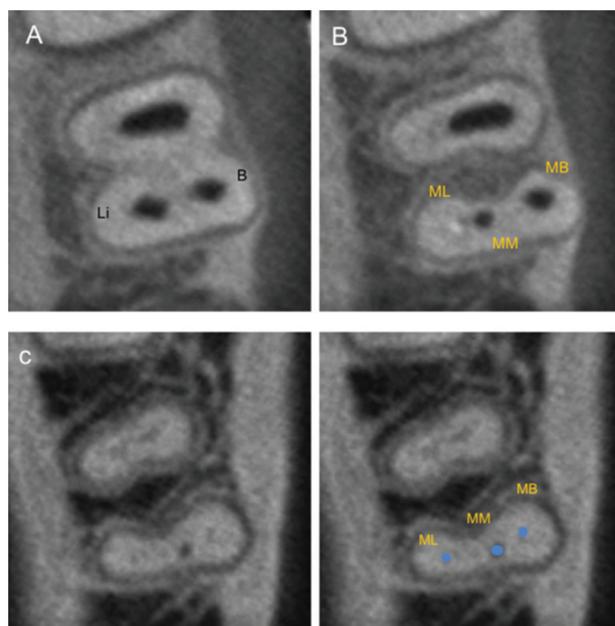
CBCT images of middle mesial canal that was the independent type: (A) At the orifice level, 2 canals were observed. (B) At 1 mm below the orifice level, there was an additional canal, which was the mesiolingual canal. The canal that was previously located next to the mesiobuccal canal was middle mesial canal. (C) At the apex of root, all three canals terminated as their own separate apical foramen. MB, mesiobuccal; MM, middle mesial; ML, mesiolingual.
